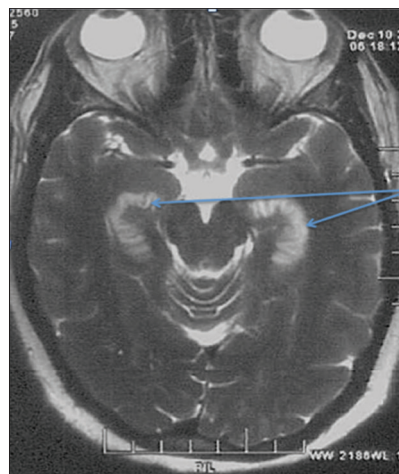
T2-weighted images showing increased hyperintensity in gyriform pattern in bilateral hippocampal region
